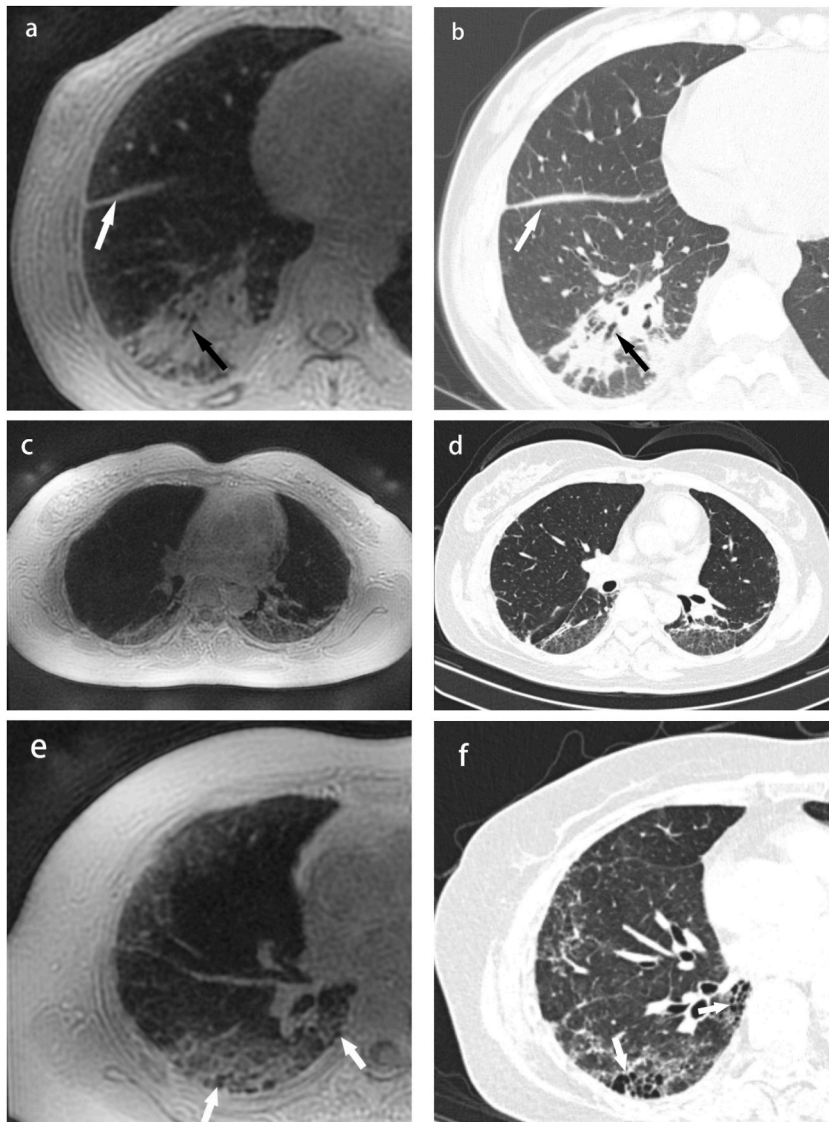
(a) Axial ZTE and (b) CT images of the lung acquired in a 39-year-old female with IPAF. Patchy high-signal replacing normal alveolar signal in the posterior basal segment of the right lower lung at ZTE image, concordant with consolidation at CT image. Besides, air bronchogram (black arrows) and effusion of pulmonary fissure (white arrows) can be demonstrated in both techniques. (c) ZTE and (d) CT images acquired in a 45-year-old female with RA-ILD. Reticular and ground-glass opacities, located at the dorsal subpleural of both lower lungs, can be detected on ZTE imaging similar to the HRCT. (e) Axial ZTE and (f) CT images of the lung acquired in a 56-year-old female also with IPAF. ZTE shows a cluster of honeycombing (white arrows) located at the dorsal subpleural of the right lower lung, in agreement with HRCT. † ZTE and HRCT images were acquired at the end of the expiratory phase and the inspiratory phase respectively, resulting in a discrepancy in the location of the lesions between the two modalities.
